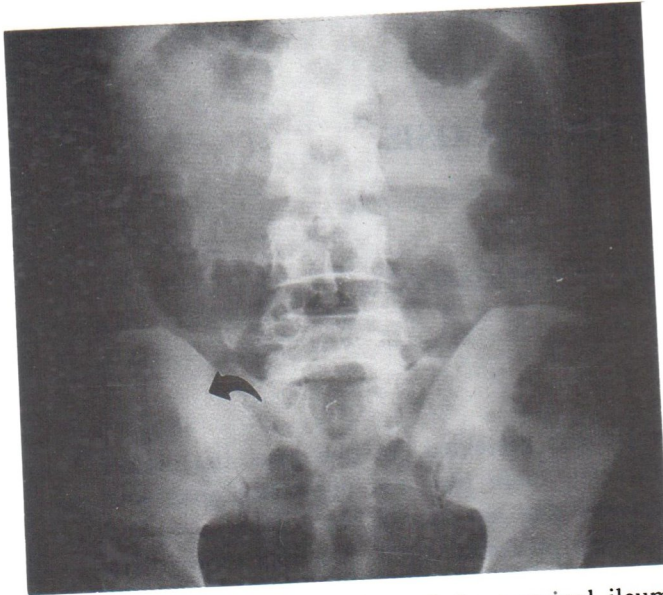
Case 1. Localized rigidity of the terminal ileum at RLQ by plain film
